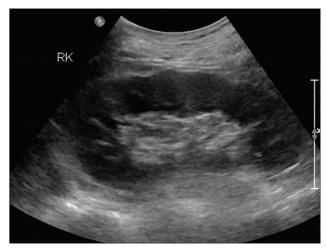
A 79-year-old male with slip down and contact burn 1 day prior. On renal ultrasonography, the right kidney showed a slightly increased size (13.4 cm), with a diffusely thickened renal cortex (18 mm) and heterogeneously decreased cortical echogenicity (blood urea nitrogen/creatinine = 23.4/0.72 mg/dL, K = 4.3 mmol/L, and activated partial thromboplastin time = 32.3 s). K: Potassium
